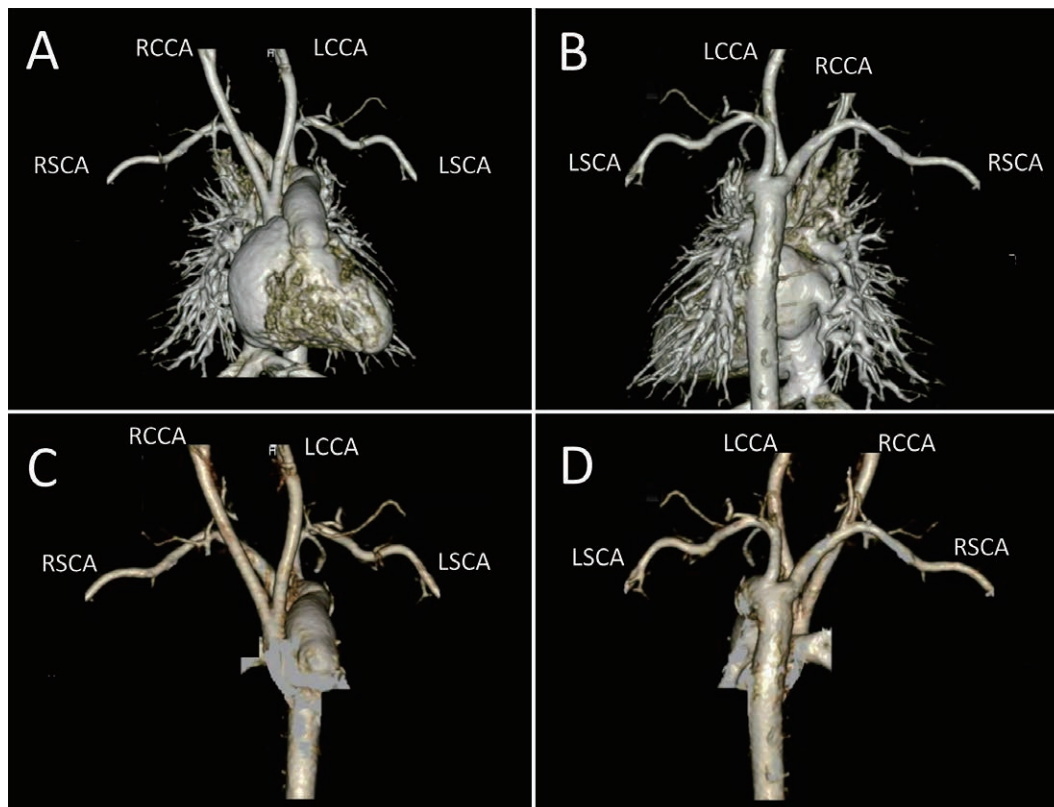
A 3D computed tomography angiography reveals that the right subclavian artery branches from the descending aorta distal to the interrupted aortic arch.
